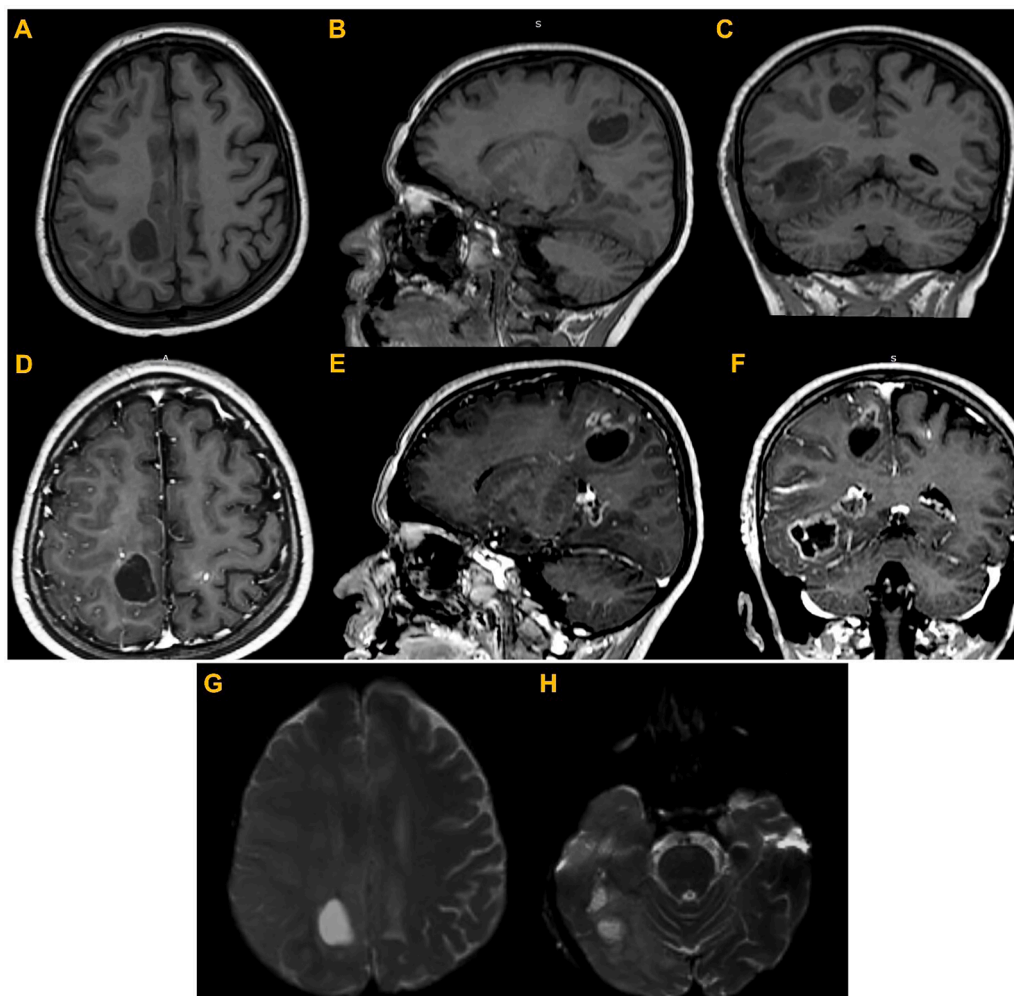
MRI of the brain. Axial, sagittal and coronal T1-weighted images (A, B & C) show a right parasagittal frontal and temporal lesions with central hypointensity. Postcontrast T1-weighted images (C,D & E) show a thin ring enhancement. On diffusion-weighted images (G & H), lesions demonstrated hyperintensity and central restricted diffusion consistent with an abscess cavity.
